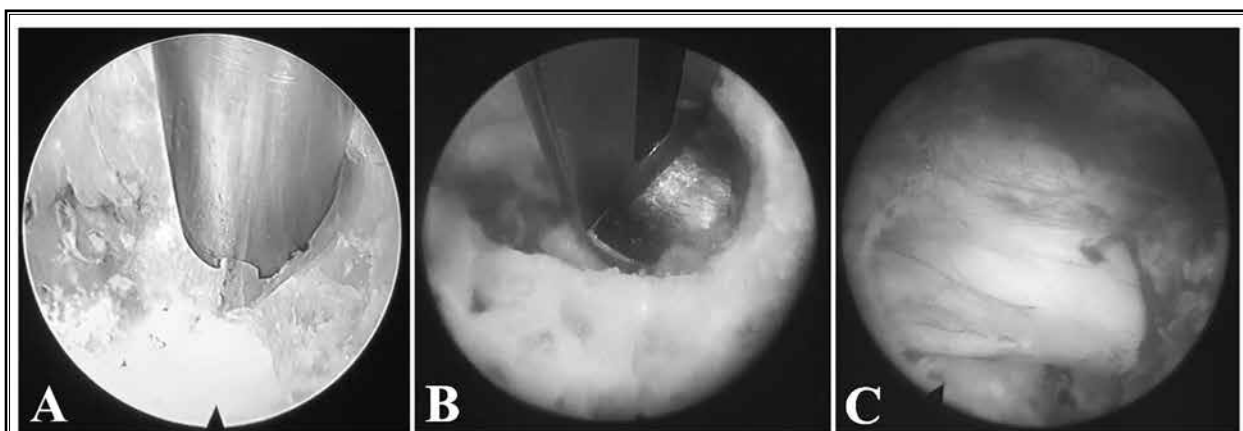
The ossified ligamentum flavum was removed safely and efficaciously layer by layer by the cavitation effect of the ultrasonic osteotome (A). For the patients without dural adhesions, the inner layer of the ossified ligamentum flavum can be removed by the endoscopic punch (B). A clear space between the dural sac and the lamina was observed after the thorough neural decompression (C).
